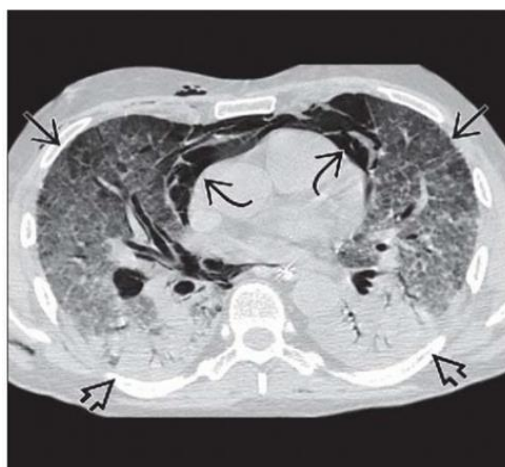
The axial CT image shows bilateral symmetric ground-glass opacities with interlobular septal thickening, predominantly central and perihilar, creating a bat-wing distribution. There is cardiomegaly (curved arrows) and bilateral pleural effusions (peripheral arrows), with dependent increased attenuation.
